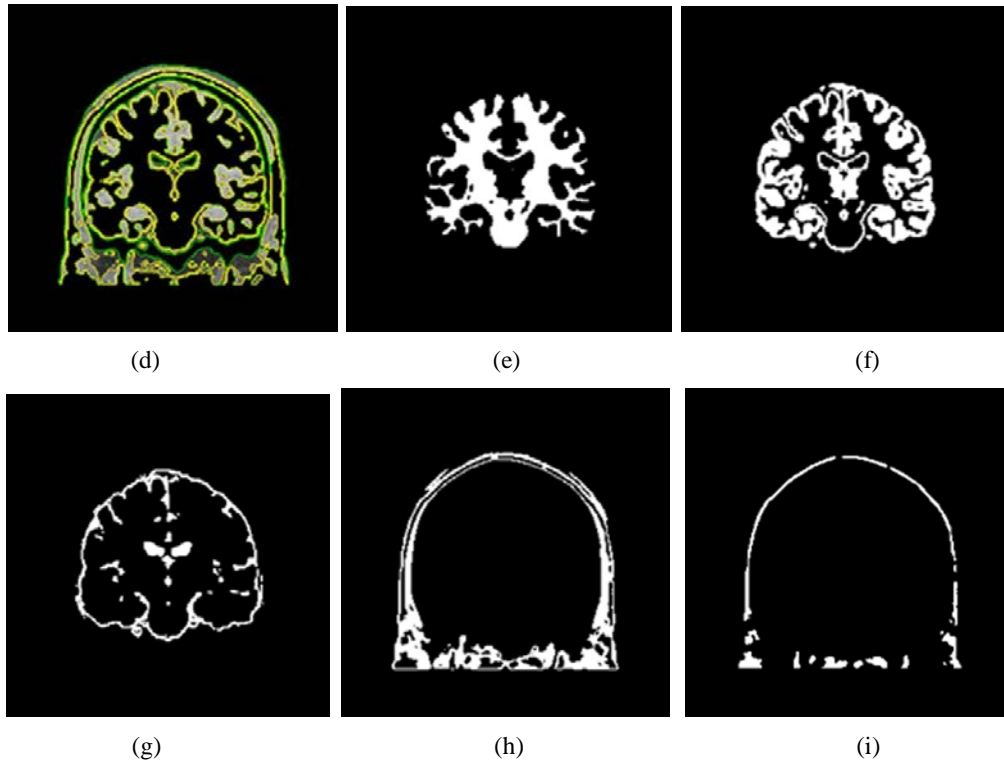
(a) Input MRI image; (b) three phase level set output performed on input image; (c) and (d) are the outputs of level set performed on segmented region of (b); (e) is the segmented white matter; (f) is segmented gray matter; (g) is segmented CSF; (h) is segmented muscle skin; and (i) is segmented marrow region of brain
